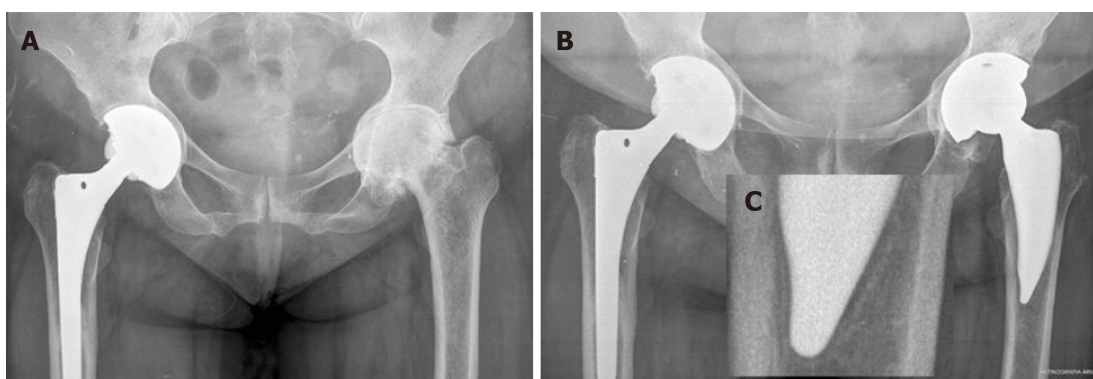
Reactive lines were observed in zones 3, 4 and 5. A: Preoperative radiographs showing "protrusion acetabuli" and Dorr type C proximal femur; B: Postoperative radiographs at two years; C: Reactive lines in zones 3, 4 and 5.
